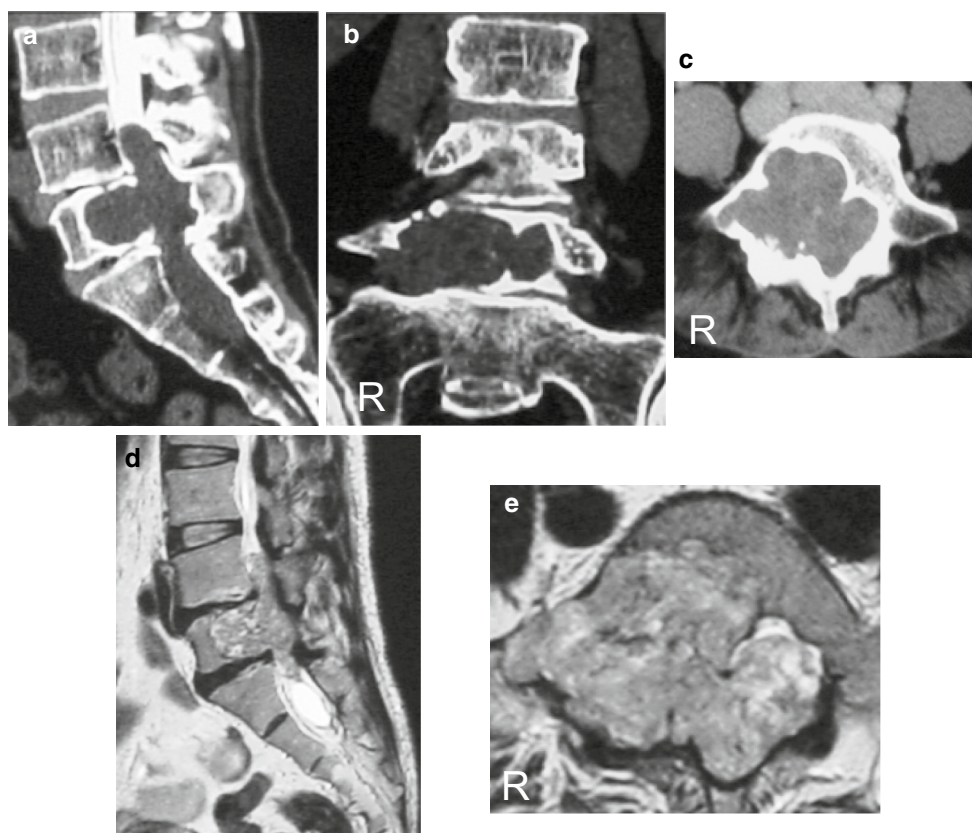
Preoperative images. Sagittal (a), coronal (b) and axial (c) views of computed tomography after myelography. T2-weighted magnetic resonance imaging with sagittal (d) and axial (e) views
